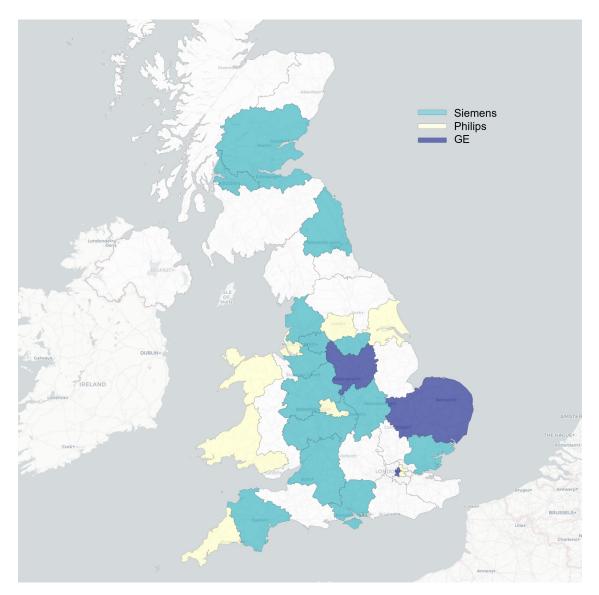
External dataset map. The external dataset was imaged at different centers in the UK using different MRI vendors and systems.
